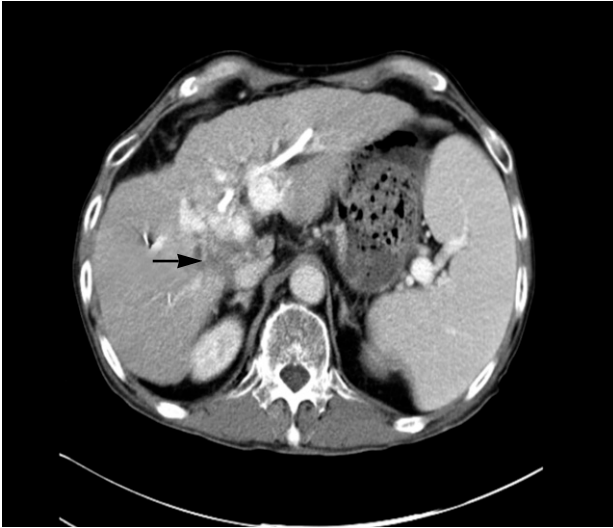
Abdominal computed tomography scan showing a slight decrease in the dimensions of the hypervascular mass involving the caudate lobe (4.8 × 3.2 cm).
